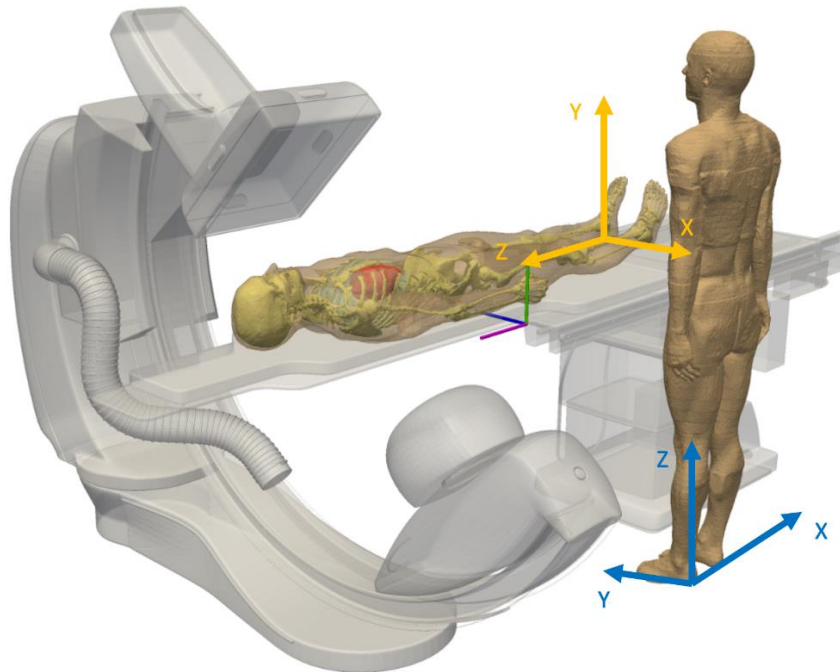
Patient and Operator reference systems in a real X-ray system
